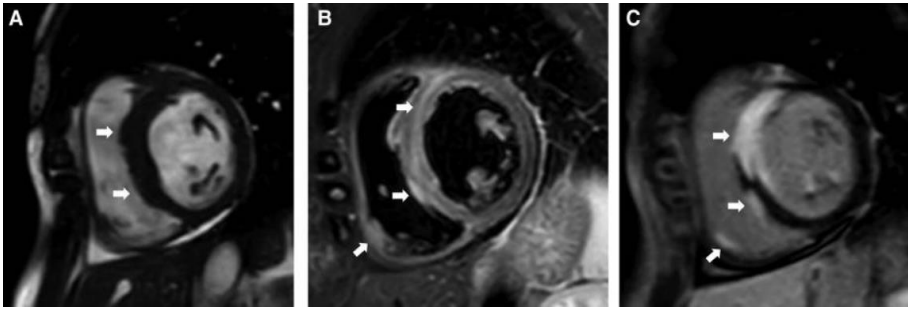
Magnetic resonance imaging scans of a patient diagnosed with cardiac sarcoidosis. A short-axis cardiac cine image displays a thickened ventricular septum (A). A T2-weighted image reveals edema in the septum and localized inflammation in the right ventricle (B). In the late gadolinium enhancement image, there is evidence of transmurular involvement in the septum, papillary muscles, and localized inflammation in the right ventricular free wall (C). *Reproduced with permission of Oxford University Press from Eur Heart J, Cardiac sarcoidosis: phenotypes, diagnosis, treatment, and prognosis, Lehtonen et al. 2023, Copyright Clearance Center.*
